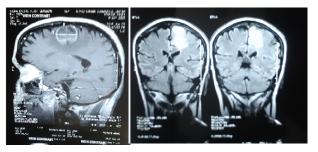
MRI with contrast taken after one year of antituberculosis treatment showing no radiologic improvement.
